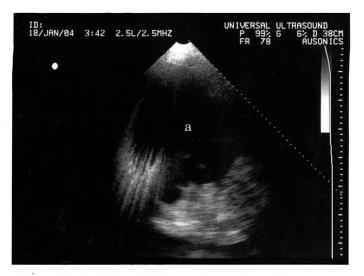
Ultrasound findings of the abdominal cavity of the bull with a ruptured urinary bladder and azotemia due to urolithiasis. Notice (a) the amount of fluid present in the cavity.
